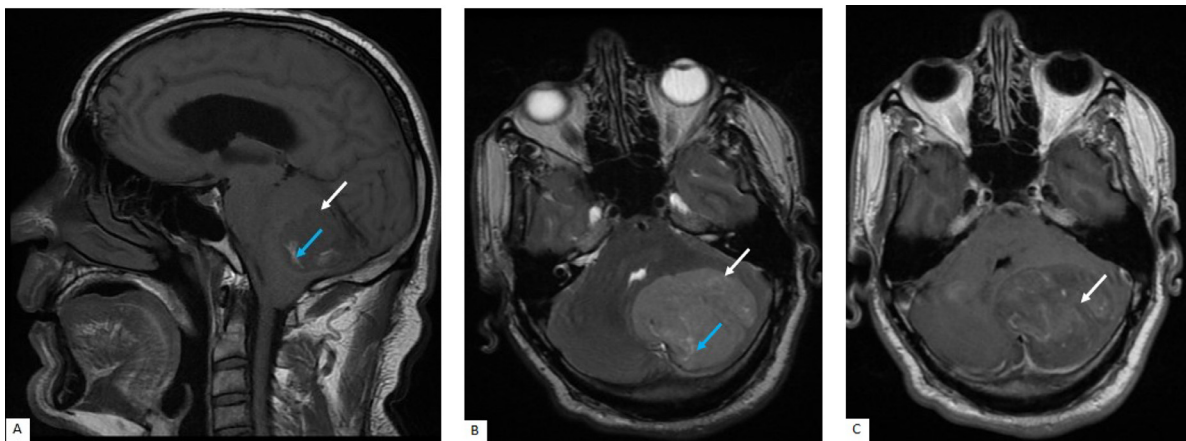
Brain MR images: Sagittal T1-WI (A), Axial T2-WI (B), Axial post contrast T1-WI, revealing a lateral well-shaped solid lesion within the left cerebellar hemisphere without apparent edema, isointense on T1-WI (A), slightly hyperintense on T2-WI (B) (white arrows), with focal areas of hyperintensity on both T1 and T2-WI (blue arrows). After administration of contrast agent (C), the tumor showed heterogeneous and minimal enhancement (white arrow). Moderate mass effect was evident, resulting in tonsillar herniation into the foramen magnum and compression of the fourth ventricle with active triventricular hydrocephalus.
